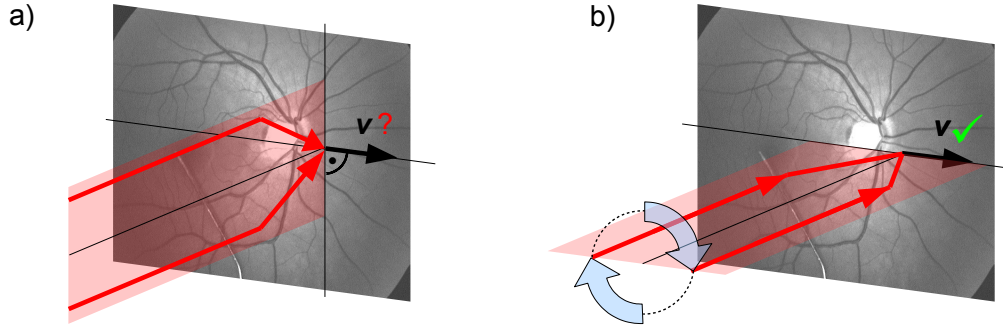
Rationale for rotating the detection plane (visualized as red transparent area) spanned by the OCT beams (red arrows) to measure a vessel's velocity vector (black arrow). a) If the vessel's velocity vector is perpendicular to the beams' plane, it does not induce a Doppler shift in the beams. Thus, the velocity cannot be determined. b) Rotating the beams aligns them with the velocity vector; a Doppler shift can occur – the velocities can be measured.
